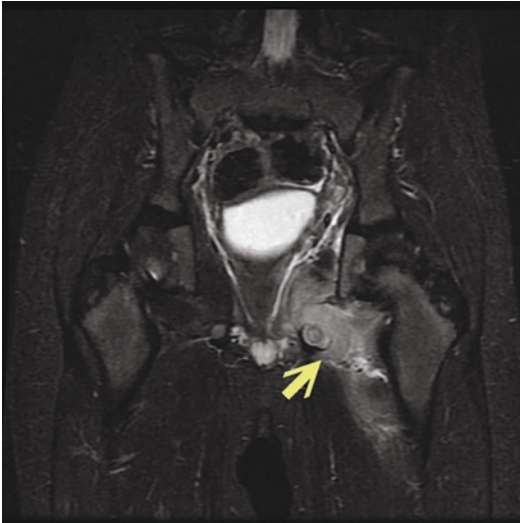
Magnetic resonance imaging showed diffuse soft tissue swelling (arrow) near the left pelvic sidewall
